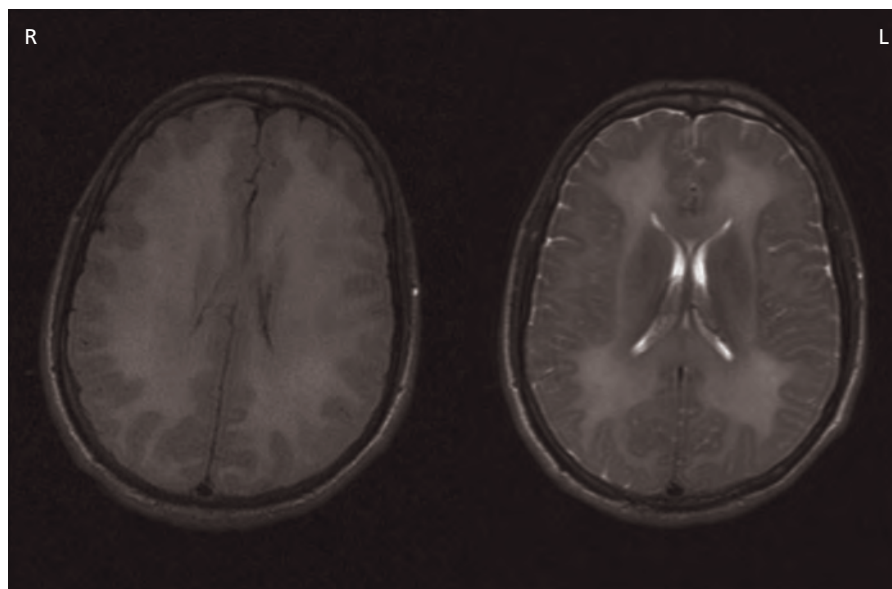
Toxic encephalopathy caused by inhalation of heroin pyrolyate. MRI T2W scan showing extensive white matter change.
